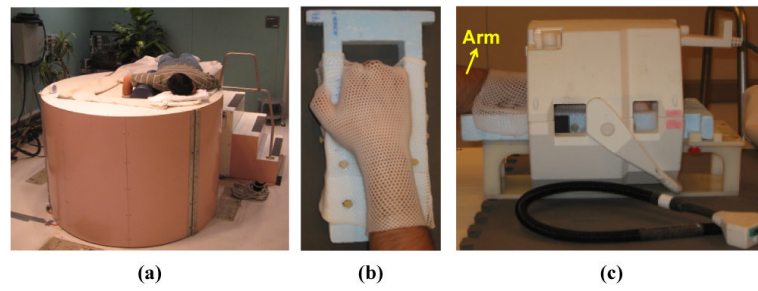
High resolution hand imaging; (a) a model on the the UC Davis high resolution extremity CT scanner, (b) the patient-specific thermoplastic immobilizer that was used for longitudinal scanning to improve repositioning, and (c) a patient's hand in the RF coil on a 1.5T MRI scanner.
